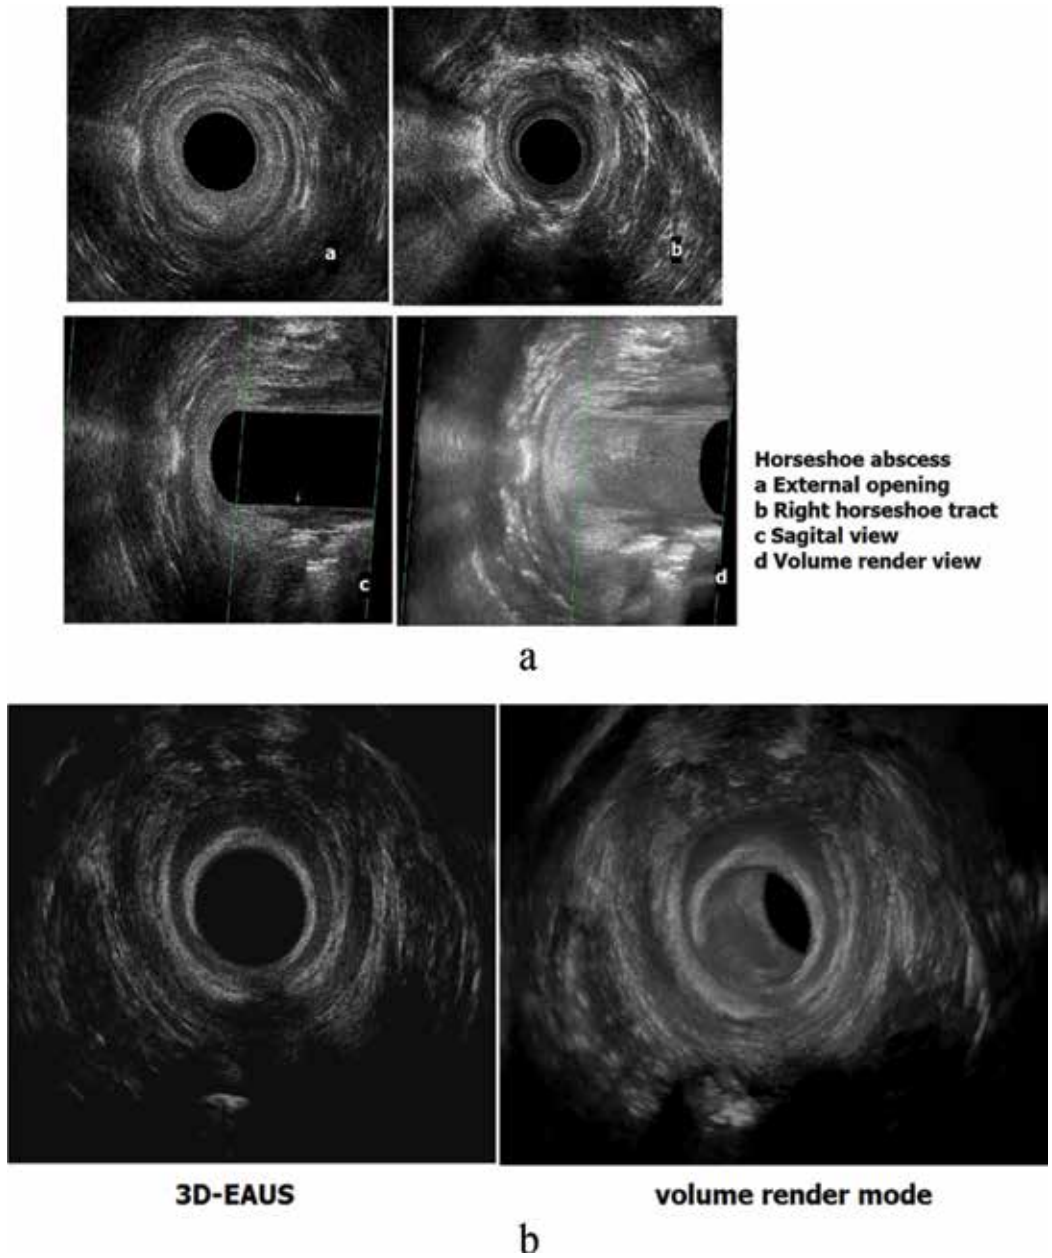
a. Endoanal ultrasound view of the right horseshoe fistula. b. 3D-EAUS view with the rendered view of postanal space abscess.
